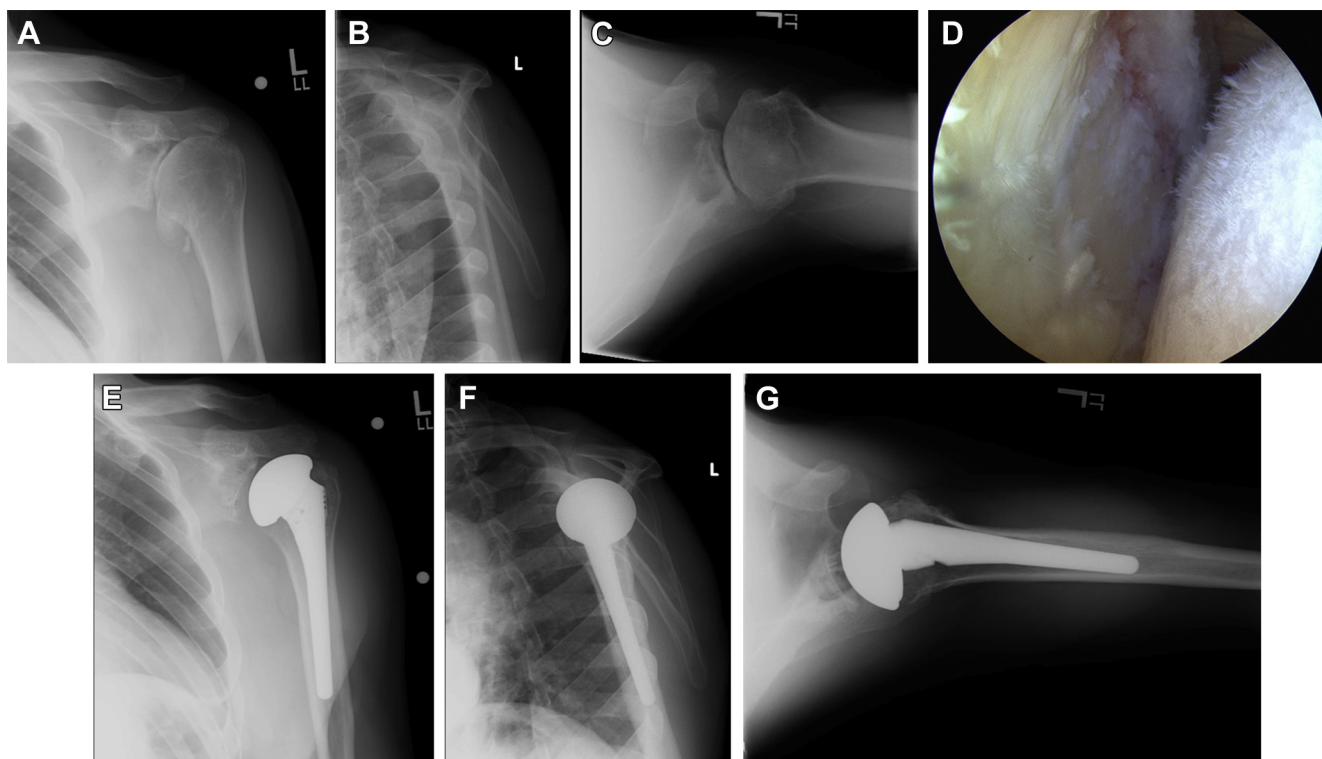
This 42-year-old man sustained a motor vehicle accident with an associated glenohumeral dislocation. An outside physician performed a labral repair, and the patient subsequently experienced intractable shoulder dysfunction, pain, and stiffness. Radiographs were obtained, including (A) Grashey anteroposterior (AP), (B) scapular Y lateral, and (C) axillary lateral views, which showed joint space narrowing, osteophyte formation, and subchondral cyst formation. (D) Arthroscopy was performed and revealed chondrolysis. The patient underwent total shoulder arthroplasty, which provided pain relief and improved range of motion. Postoperative films at 6 months showed a well-fixed and well-aligned prosthesis on (E) Grashey AP, (F) scapular Y lateral, and (G) axillary lateral views.
